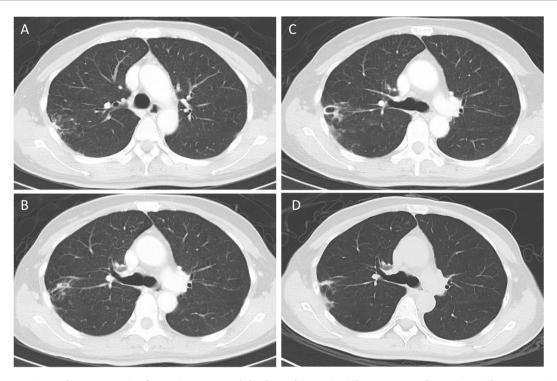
Progressive pulmonary cavity formation over nodular bronchiectatic (NB) area, namely cavitary NB pattern, in a 51-yearold woman with minimal symptoms under regular radiographic follow-up. Her sputum samples were AFB smear positive and culture positive for MAC at the time of cavity formation. (A) Three years before this presentation, chest CT reveals tree-in-bud lesions in the right upper lobe. (B) There were also minimal fibrotic changes at a slightly lower level of the NB area, suggesting repeated inflammation. (C) Presentation chest CT at the same level as (B) discloses a newly developed right upper lobe cavity. (D) Chest CT after 6 months of daily anti-MAC therapy with azithromycin, ethambutol, and rifampin demonstrates regression of tree-in-bud lesions and near resolution of the cavity in right upper lobe.
